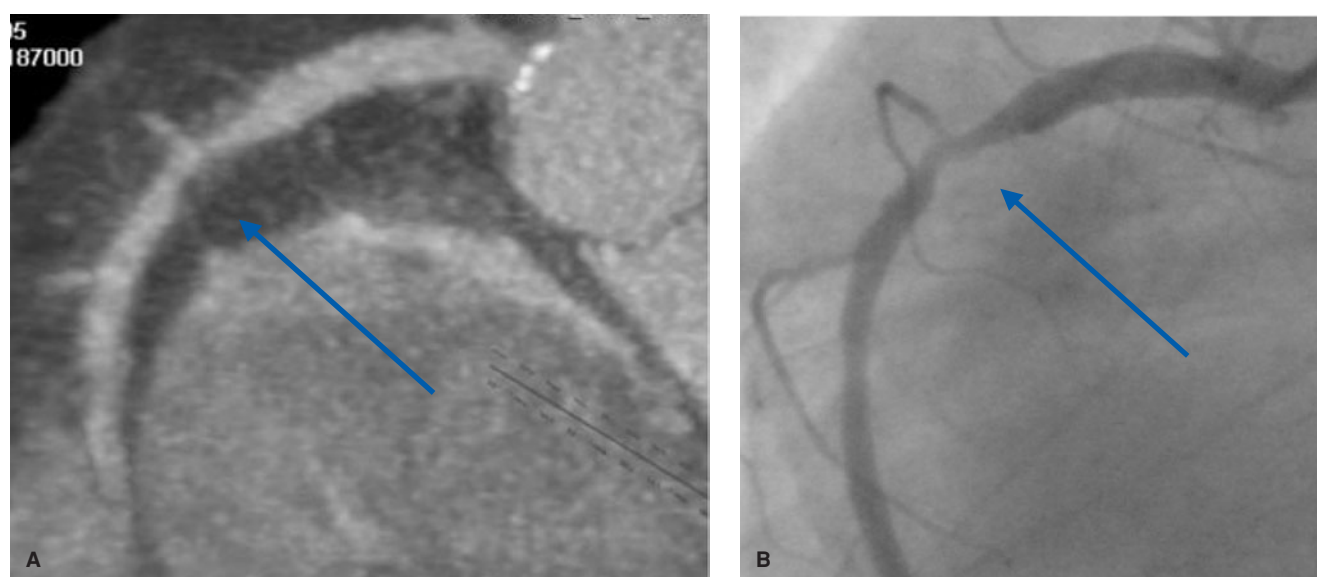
Proximal RCA 50% stenosis diagnosed by coronary CTA and confirmed by conventional angiography. Double oblique maximum-intensity projection image (4 mm thick) through proximal RCA (A) and LAO projection still image from conventional angiogram (B) demonstrate a segment of approximately 50% stenosis (arrows).
